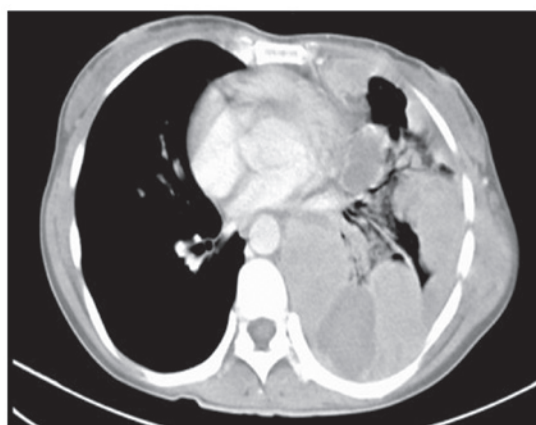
Computed tomography scan revealing a large mass with an unclear boundary infiltrating the interspace of the mediastinum.
